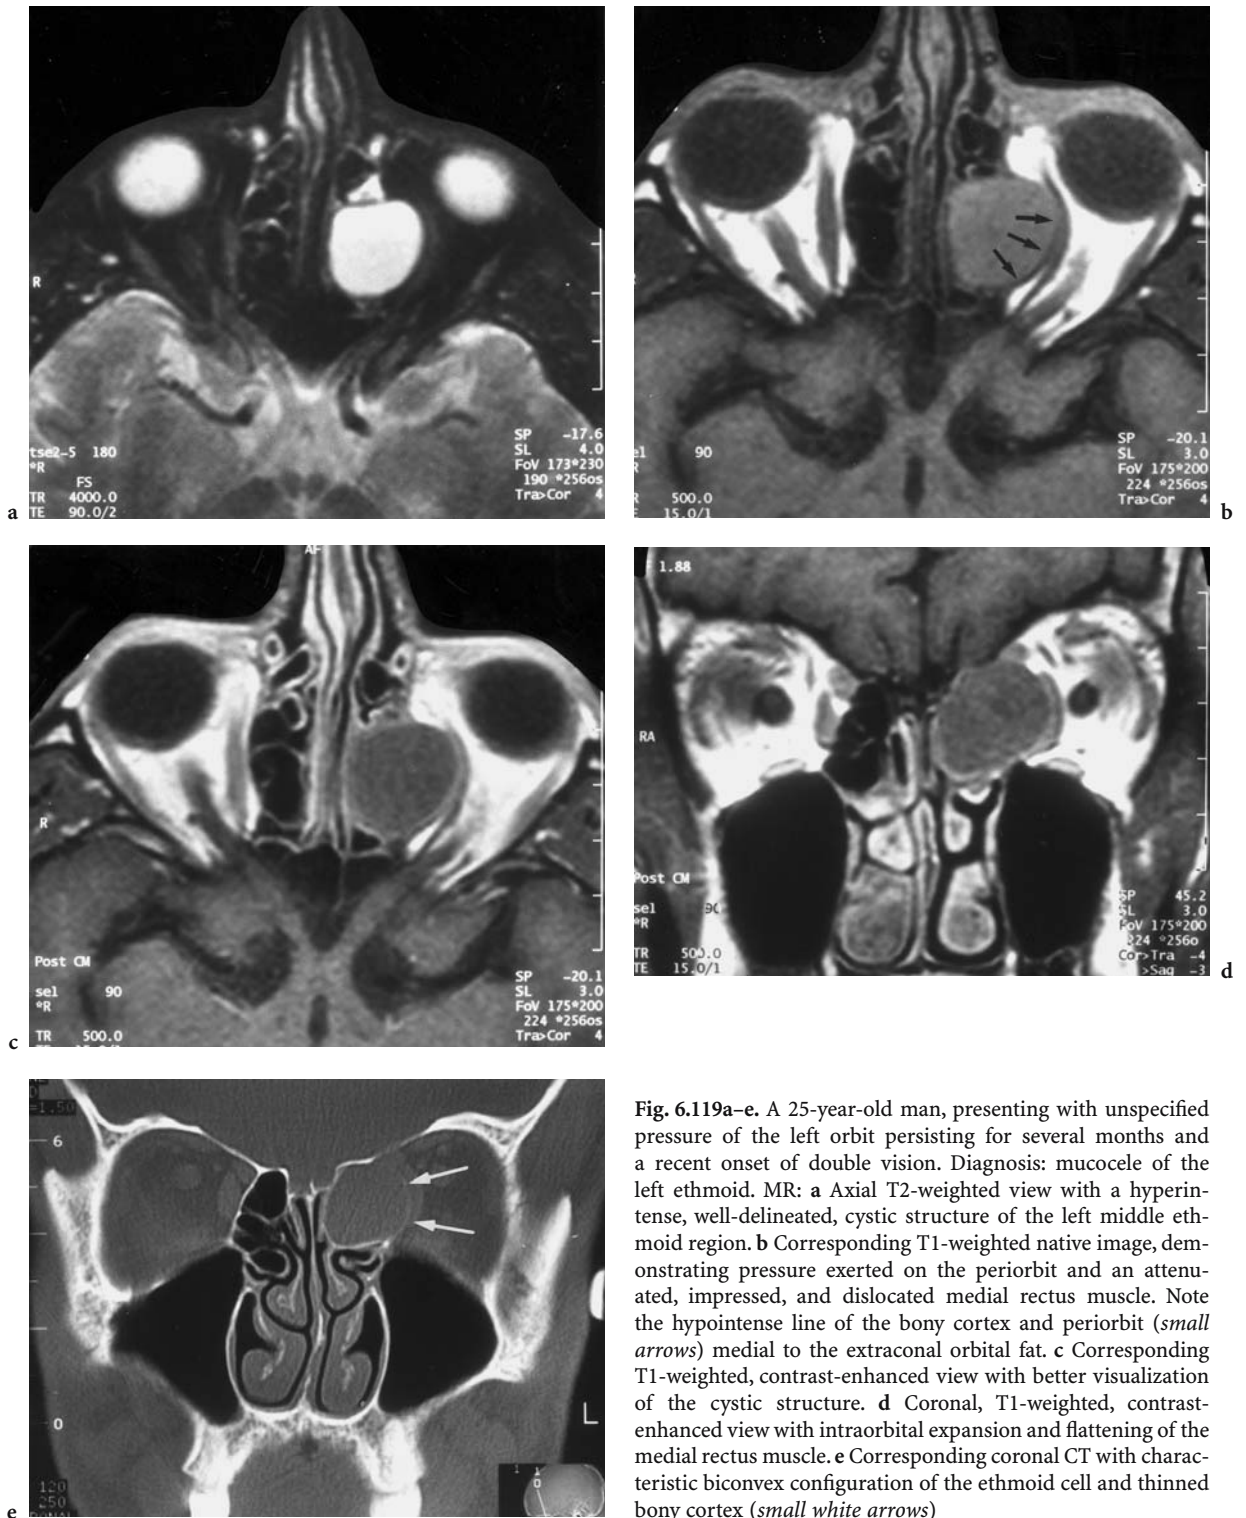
A 25-year-old man, presenting with unspecified pressure of the left orbit persisting for several months and a recent onset of double vision. Diagnosis: mucocele of the left ethmoid. MR: a Axial T2-weighted view with a hyperintense, well-delineated, cystic structure of the left middle ethmoid region. b Corresponding T1-weighted native image, demonstrating pressure exerted on the periorbit and an attenuated, impressed, and dislocated medial rectus muscle. Note the hypointense line of the bony cortex and periorbit (*small arrows*) medial to the extraconal orbital fat. c Corresponding T1-weighted, contrast-enhanced view with better visualization of the cystic structure. d Coronal, T1-weighted, contrast-enhanced view with intraorbital expansion and flattening of the medial rectus muscle. e Corresponding coronal CT with characteristic biconvex configuration of the ethmoid cell and thinned bony cortex (*small white arrows*)
